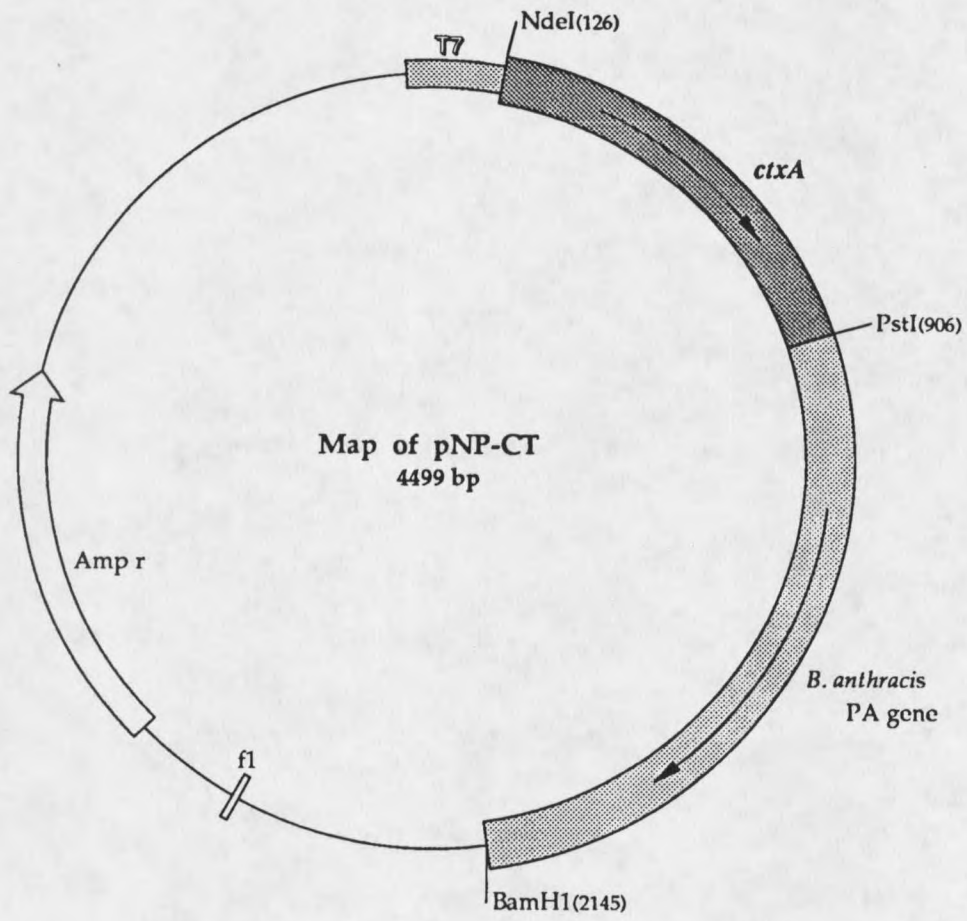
Map of plasmid pNP-CT.
